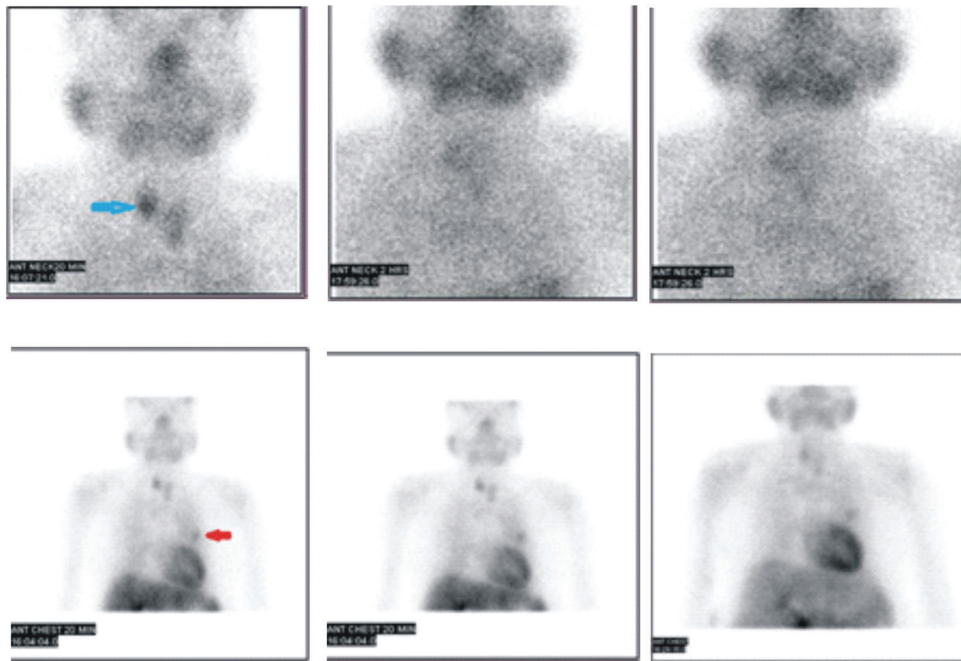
Tc99m MIBI scintigraphy postoperatively showed an area of radiotracer retention in the region of upper pole of right lobe of thyroid gland (blue arrows), compatible with diagnosis of parathyroid adenoma. Another focus of increased uptake in left side of chest (red arrows).
